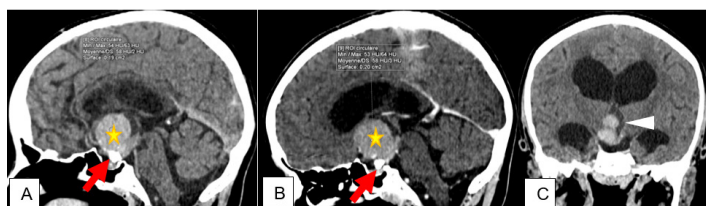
In this 14-year-old patient, CT scan showed a mixed suprasellar lesion, with calcification (arrow), hemorrhage (star) not enhanced after injection and cystic (arrowhead) in favor of a hemorrhagic craniopharyngioma. Compression of V3 is responsible for biventricular hydrocephalus.
